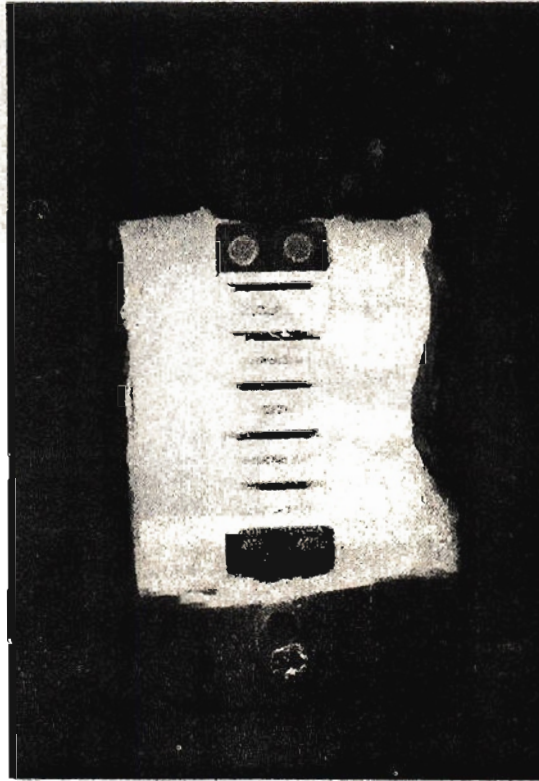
High-resolution Faxitron x-ray of intact 12-week implant with surrounding bone intact, demonstrating complete bone ingrowth across all plasma-HA-lined channels, with only 40-50% filling of the alternating CP-titanium-lined channels
